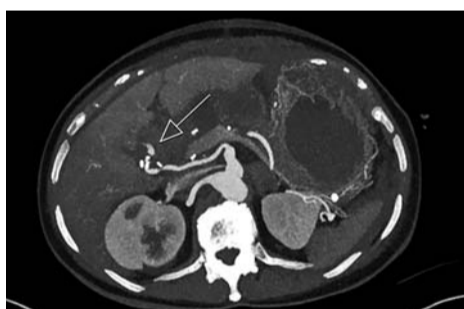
Hepatic artery bleeding (CTA)
